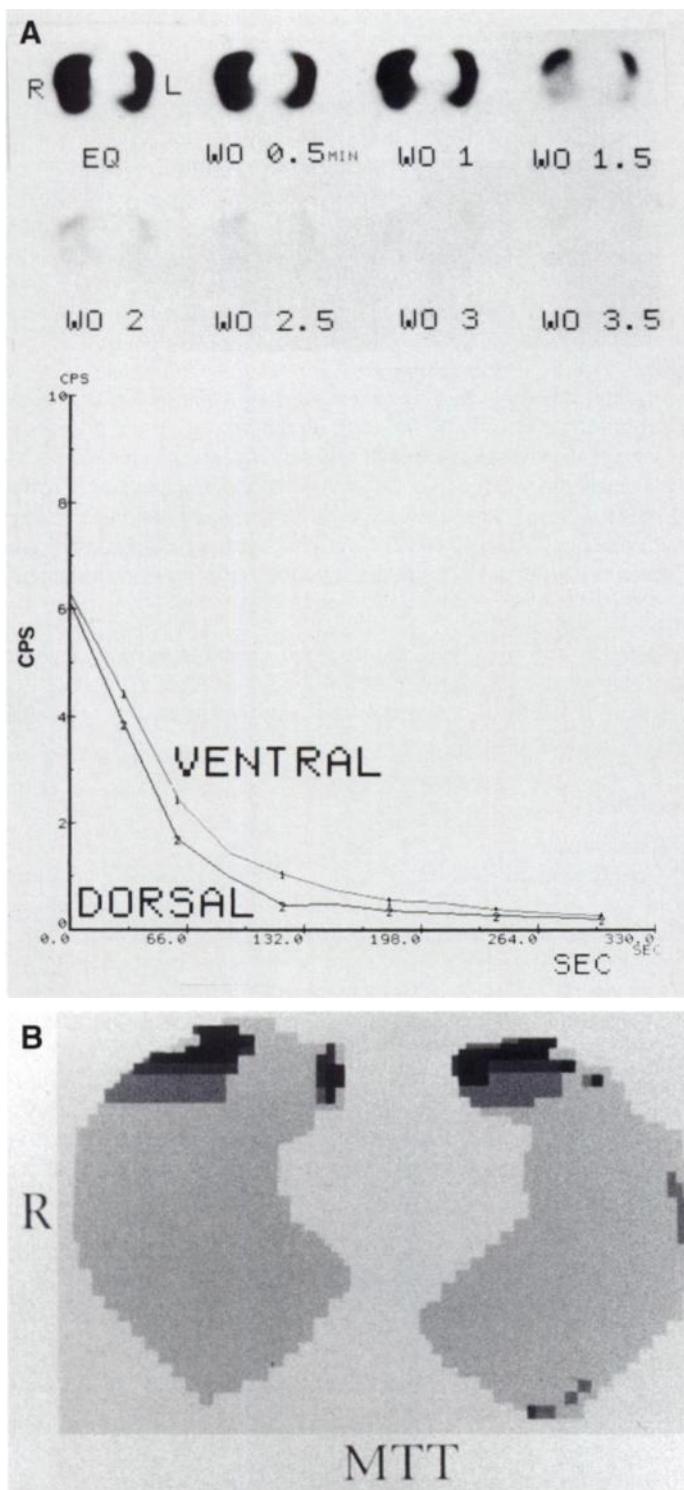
(A) Sequence of transaxial equilibrium and washout (0.5–3.5 min) SPECT at lower lung level in a volunteer (above). Early washout images (0.5–2.0 min) show greater ^{133}Xe activity in ventral than dorsal portion. Washout curves in right lung reveal that $T_{1/2}$ (53.5 sec) in ventral portion is longer than dorsal portion (42.8 sec) (bottom). (B) MTT image shows prolonged MTT in ventral portions (greater MTT magnitude is reflected by darker pixel color).
